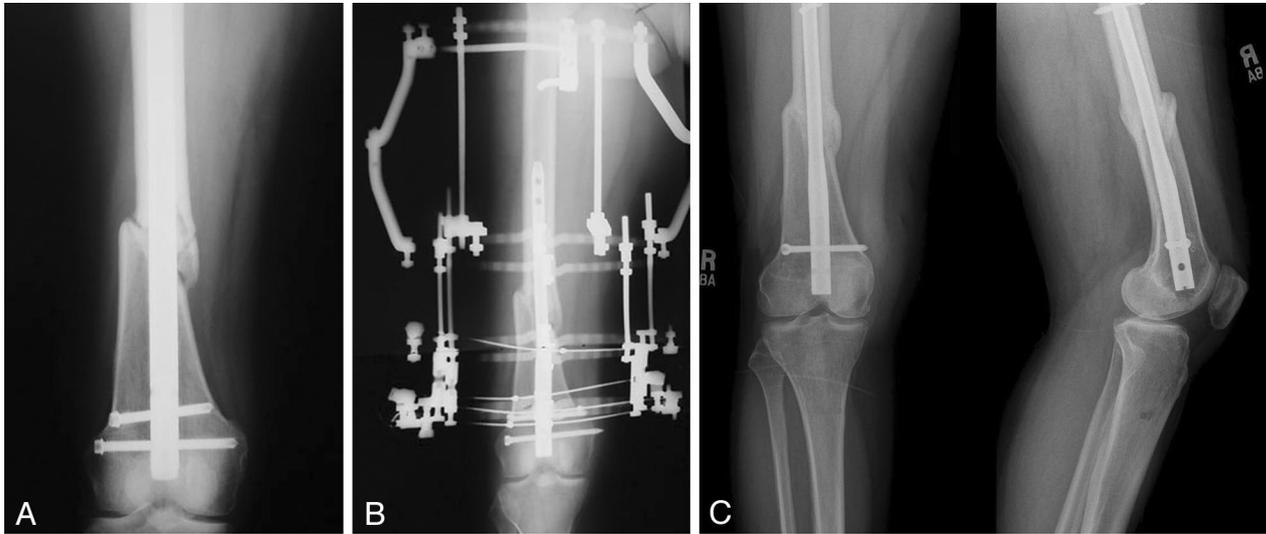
Failure of exchange nailing. (A) Anteroposterior radiograph of a 39-year-old woman with a history of a fracture treated with a retrograde nail. Despite the somewhat benign appearance of the fracture, this patient was referred in having failed two prior attempts at exchange nailing. The patient presented with severe thigh and knee pain rated as 9 out of 10. (B) Anteroposterior radiograph following placement of an Ilizarov external fixator over a smaller diameter retrograde intramedullary nail dynamically locked with screw fixation only distally. Note the bending of the distal Ilizarov wires indicating good compression at the nonunion site using the SCONE (slow compression over a nail using external fixation) technique. Also note the improved bony contact at the nonunion site. (C) Final anteroposterior and lateral radiograph showing solid bony union following static locking of the nail and removal of the Ilizarov external fixator. The patient has resumed full preinjury activity and rates her pain at 0 out of 10.
